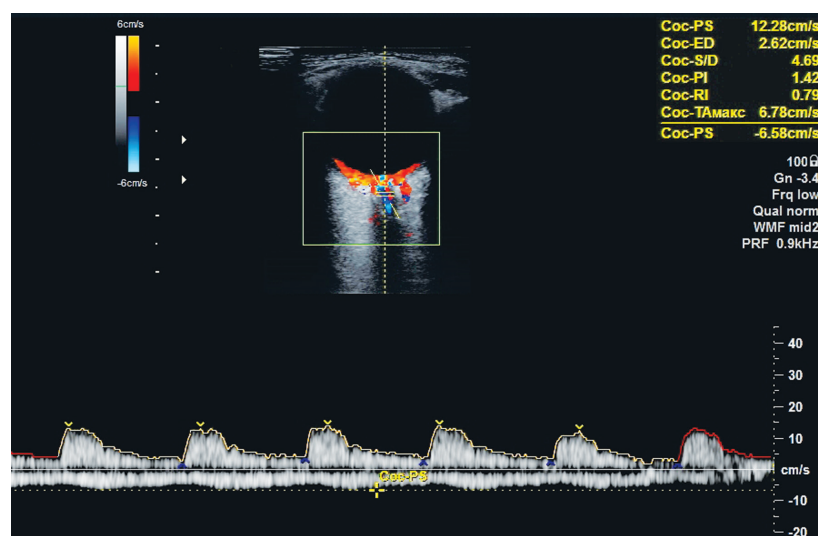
Eye and orbit color flow and pulsed wave Doppler images: blood flow in the center of the optic nerve shadow near the posterior pole represents the central retinal artery (CRA) and central retinal vein (CRV). Doppler images of blood flow in the CRA (above the baseline) and CRV (below the baseline). CRA blood flow parameters: PSV 12.28 cm/s; EDV 2.62 cm/s; RI 0.79.
